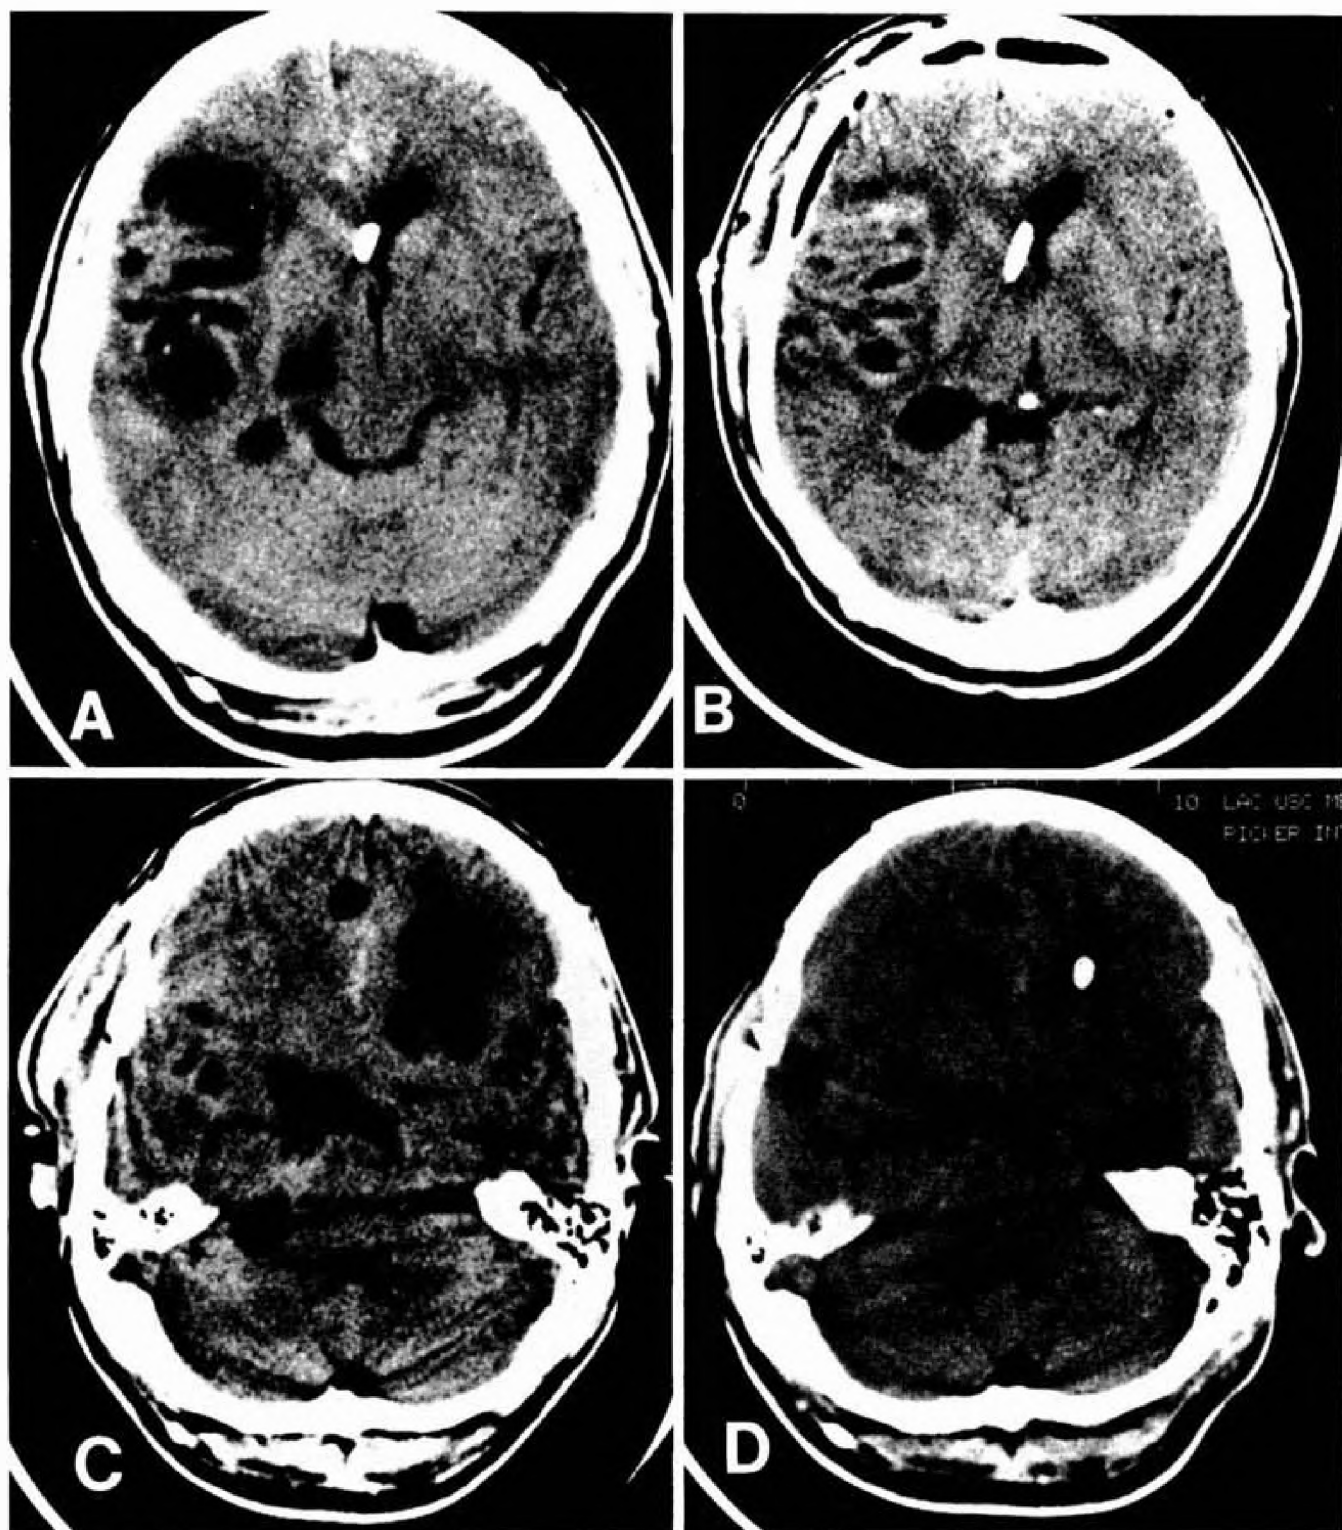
A 49-year-old man with progressive headache and gait ataxia. The patient had previously undergone ventriculoperitoneal shunting for intraventricular involvement. A CT scan done at admission revealed large right Sylvian cisternal cysts (A). A right frontotemporal craniotomy was performed for removal of multiple cysts (B). Postoperatively, the patient's symptoms resolved, but he was admitted again after 8 weeks with progressive headache. A CT scan at that time demonstrated resolution of the Sylvian lesions but showed a large left frontal parenchymal cyst that had developed in the interim (C). Stereotactic aspiration and placement of a cyst catheter-reservoir was undertaken to decrease the mass effect. A follow-up CT scan 4 months after craniotomy demonstrated no recurrence of frontal or cisternal lesions (D).
